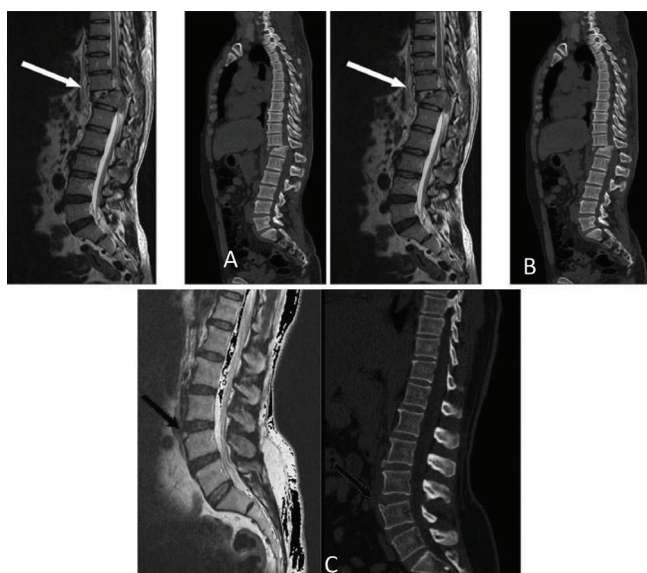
A - T2 weighted Sagittal MRI and Sagittal Reconstructed CT Image shows Comminuted fracture of D12 with retropulsion of body and extension of fracture into posterior elements. B - Sagittal T2 weighted MRI and Sagittal Reconstructed CT Image shows Anterior Wedge Compression fracture noted in the body of the L1 Vertebra seen extending into posterior elements with T2/STIR hyperintense marrow signal changes. C - Sagittal T2 weighted MRI and Sagittal Reconstructed CT Image shows Limbus deformity noted in anterior superior margin of L4 vertebra.
